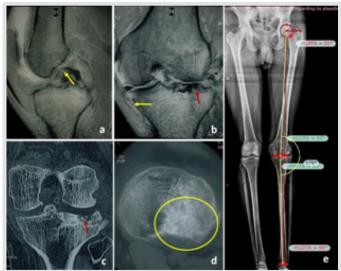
Imaging of Case 3 at presentation: (a) Magnetic resonance imaging (MRI) scan protondensity fat-saturated sagittal section shows mid-substance rupture of the anterior cruciate ligament (yellow arrow). (b) MRI scan proton-density fat-saturated coronal section showing complete rupture of medial collateral ligament (yellow arrow) and degenerative changes in the lateral compartment with absent lateral meniscus (red arrow). (c and d) CT scan showing the osseous deformity in the posterolateral tibia in coronal (red arrow) and axial (yellow circle) sections. (e) Anteroposterior scanogram shows valgus malalignment with the hip-knee-ankle axis passing lateral to the lateral tibial spine on the left side and osteotomy planning with TraumaCad software.
